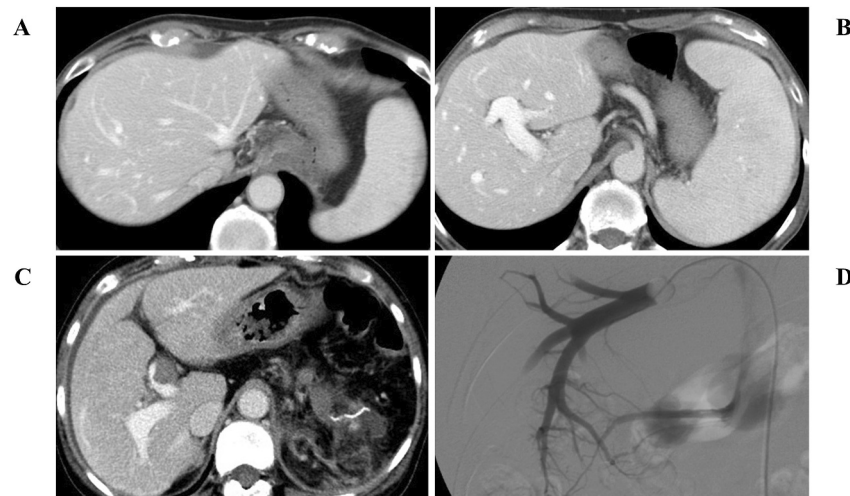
Contrast-enhanced computed tomography (CT) images of the abdomen and hepatic venography. (A) Contrast-enhanced portal phase CT. The portal vein approaches the hepatic surface as a result of atrophy of the hepatic parenchyma in the subcapsular area. (B) Contrast-enhanced CT in the portal phase. The thick right portal vein runs close to the hepatic surface due to compensatory central enlargement. (C) Portal phase contrast-enhanced CT showing the peripheral portal vein running near the surface of the right lobe of the liver and thrombus in the left branch of the portal vein. (D) Hepatic venography shows anastomosis between veins and weeping willow-like changes.
